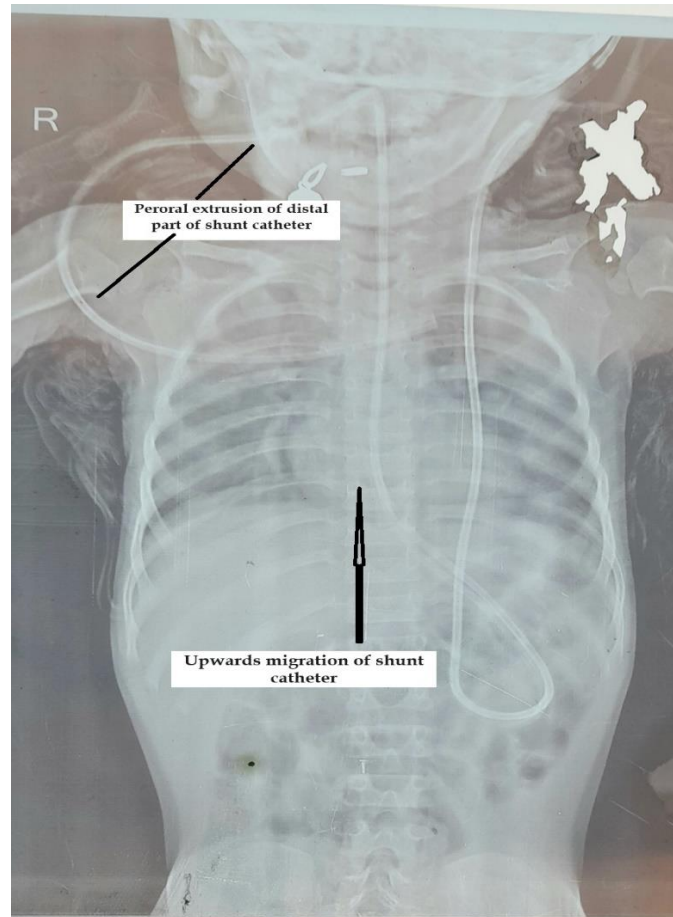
Plain X-ray of child's head, chest and abdomen showing upward migration and peroral extrusion of the distal cerebrospinal fluid shunt catheter.
